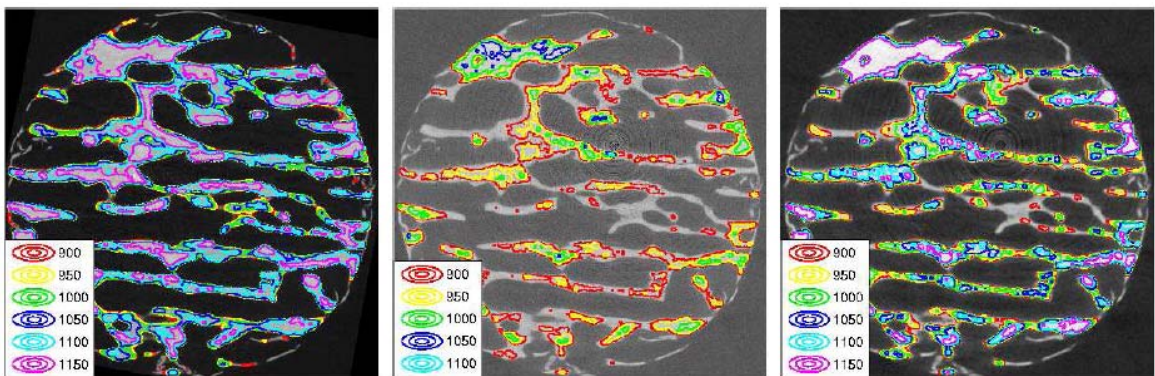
The registered SR μ CT (left), the μ CT (middle) TMD topography maps for one slices of corresponding structures. Each color corresponds to a level of TMD in mgHA/cm³ specified. The μ CT
